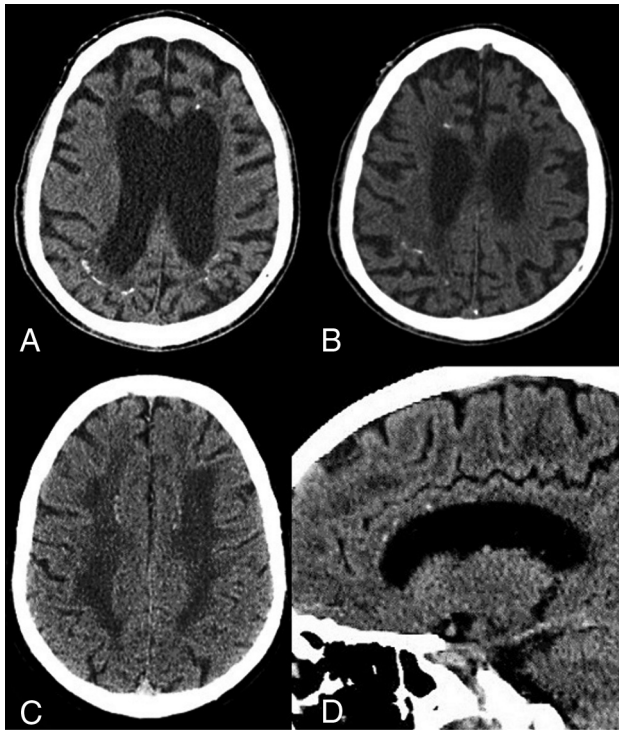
Small calcifications in ALSP. CT images reveal punctate calcifications located in the subcortical parietal WM and the periventricular frontal WM (A–C). Sagittal reconstruction shows the typical stepping stone distribution (D).
